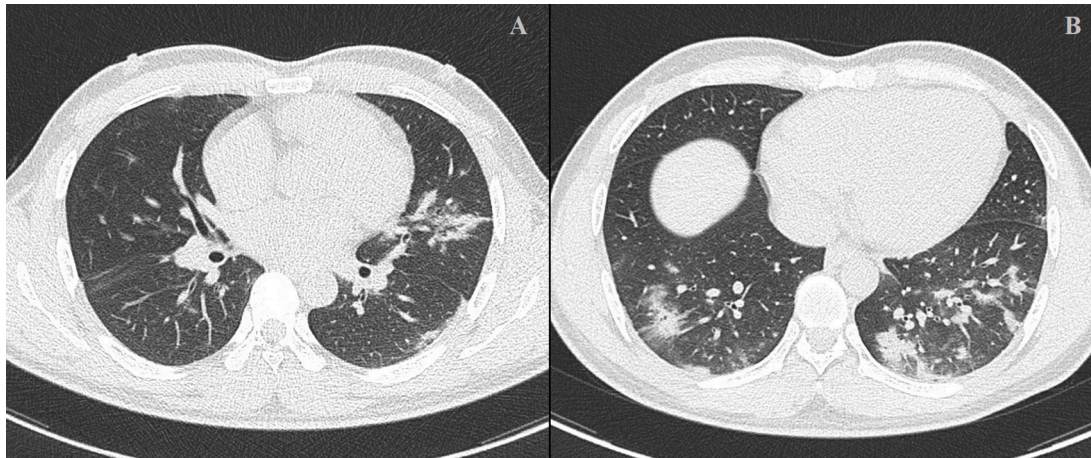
A and B. Chest CT scan showed multiple bilateral sub pleural ground glass opacities with areas of consolidation.
